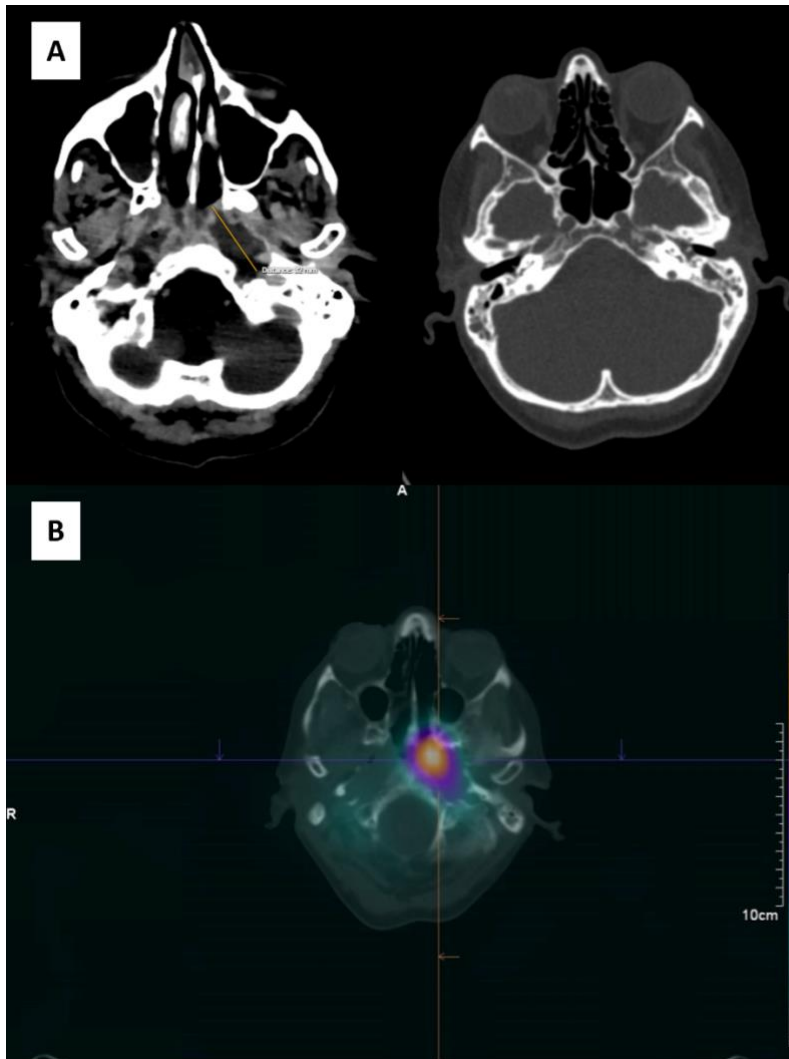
(A) Contrast-enhanced CT scan of the head showing a left-sided retropharyngeal mass with a peripheral hyperdense rim and central hypodensity. Bone window reconstruction demonstrates extensive osteolysis involving the sphenoidal clivus and the apex of the petrous portion of the left temporal bone. (B) Autologous leukocyte scintigraphy demonstrating intense radiotracer uptake in the retropharyngeal region, consistent with focal leukocyte accumulation.
